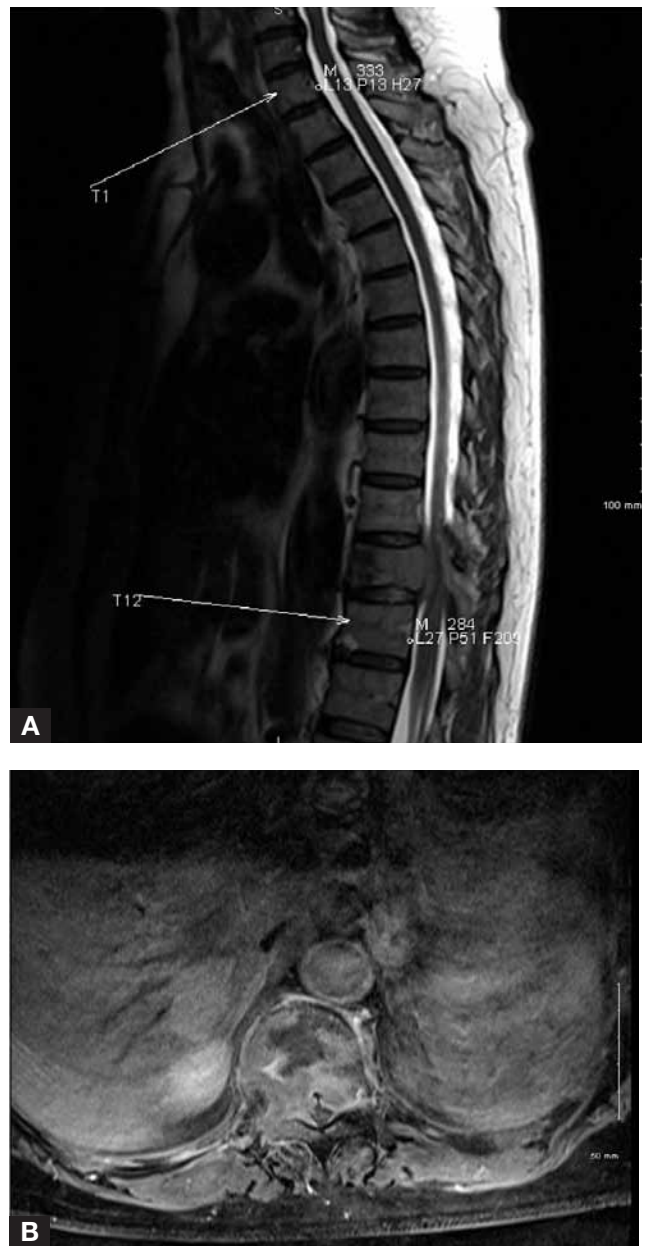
Preoperative sagittal (A) and axial (B) magnetic resonance imaging of T11 solitary spinal metastasis caused by breast cancer. Patient had rapid-onset paresis and lost the ability to walk.
